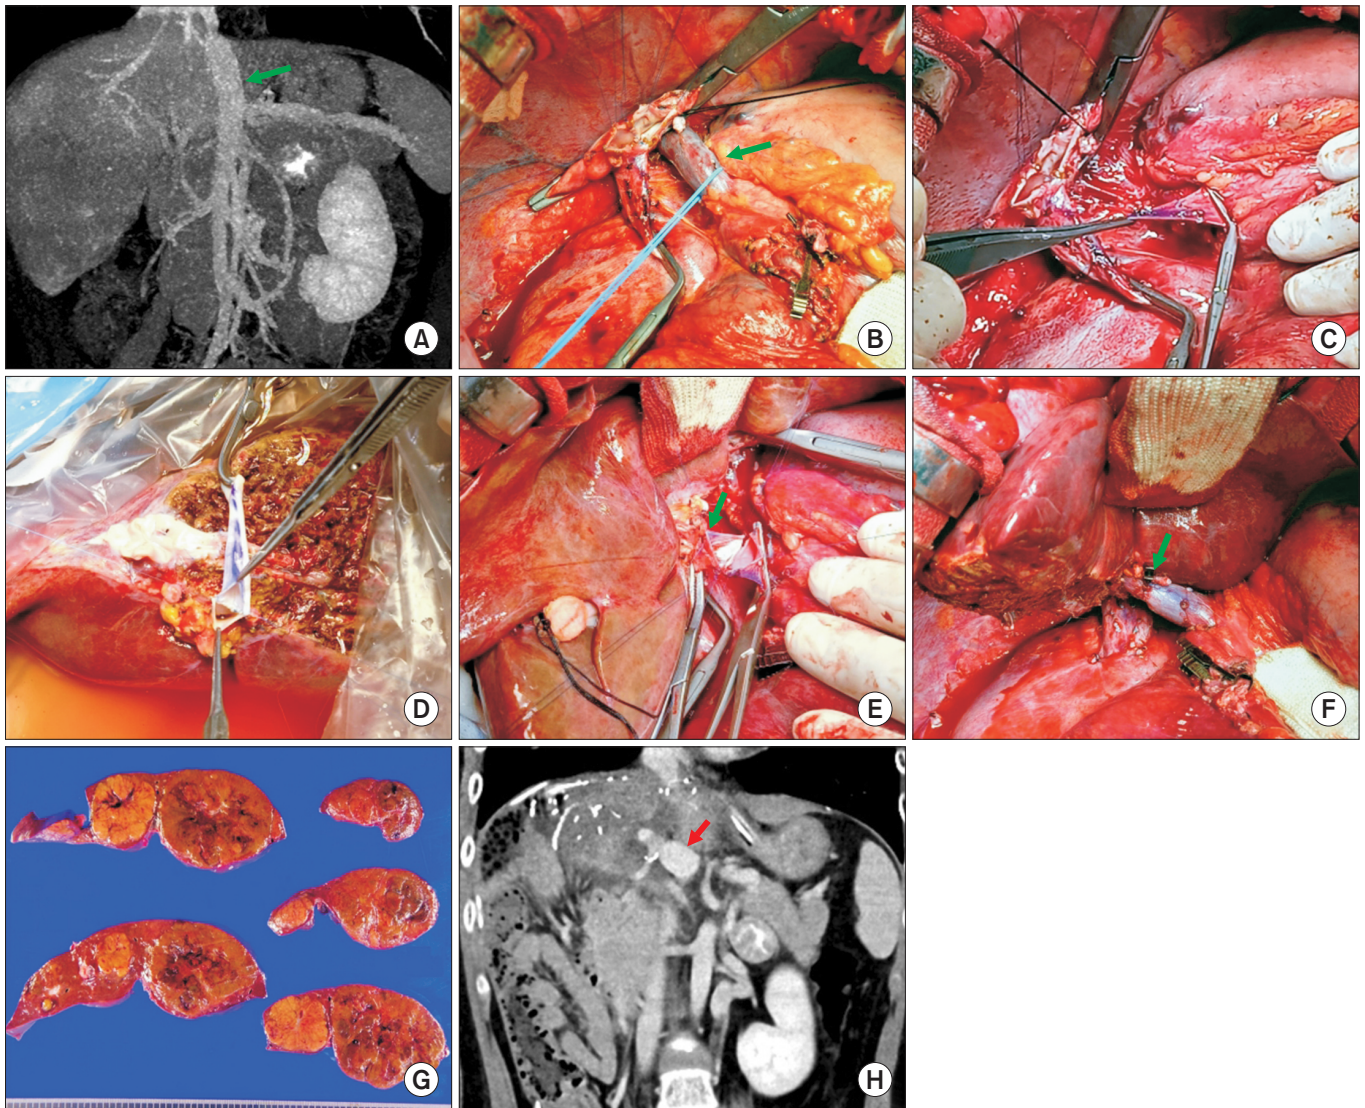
Image summary of living donor liver transplantation case 3. (A) Pretransplant computed tomography (CT) demonstrated congenital absence of the portal vein with development of a large portocaval shunt to the suprahepatic inferior vena cava (arrow). (B) A large portocaval shunt vein was isolated along the caudate process area (arrow). (C) The isolated shunt vein was transected, but was too short for direct anastomosis to the graft portal vein. (D) An iliac vein segment was anastomosed to the graft portal vein. (E) The interposed iliac vein conduit was obliquely trimmed to match the length and axis of the excised shunt vein. (F) A 1-cm wedge-shaped iliac vein segment (arrow) was interposed between the graft portal vein and shunt vein stumps to avoid redundancy. (G) Gross photograph of the explanted liver showed multiple nodules. (H) Posttransplant CT obtained 14 days later showed a streamlined configuration of the reconstructed portal vein. Reproduced from Namgoong et al. *Ann Liver Transplant* 2023;3:35-43. [8]
